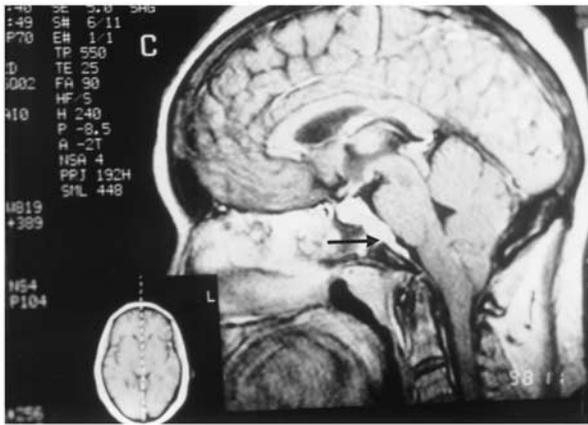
Sagittal magnetic resonance imaging demonstrating extradural enhancing lesion of the brainstem (arrow).
